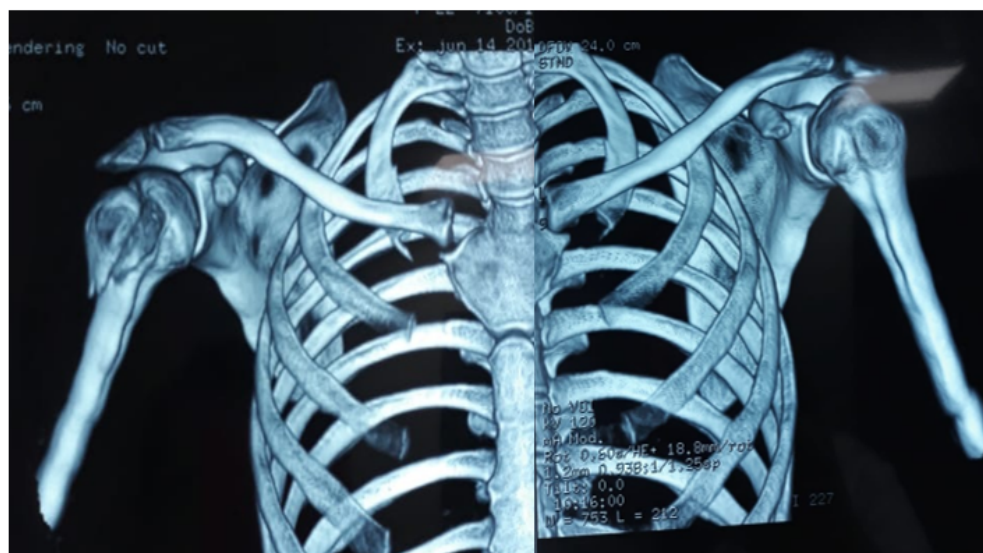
Bilateral shoulders CT-Scan showing a good reduction
